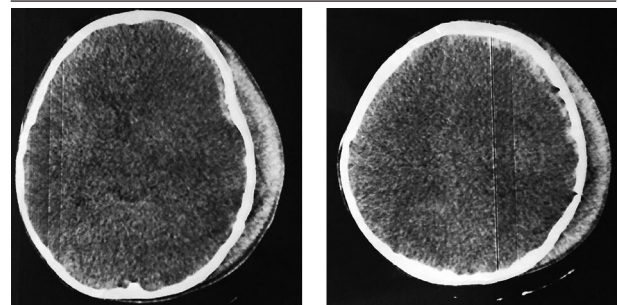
Brain Computed Tomography on the Day of Admission Showing a Small Subdural Hematoma
